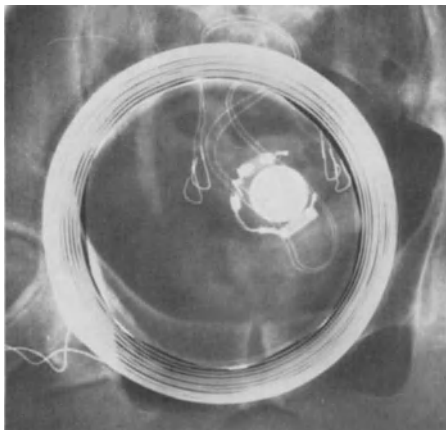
Male, 30 years, spinal cord injury. Radiography of the pelvis. Details of the neurostimulator and inductor antenna
